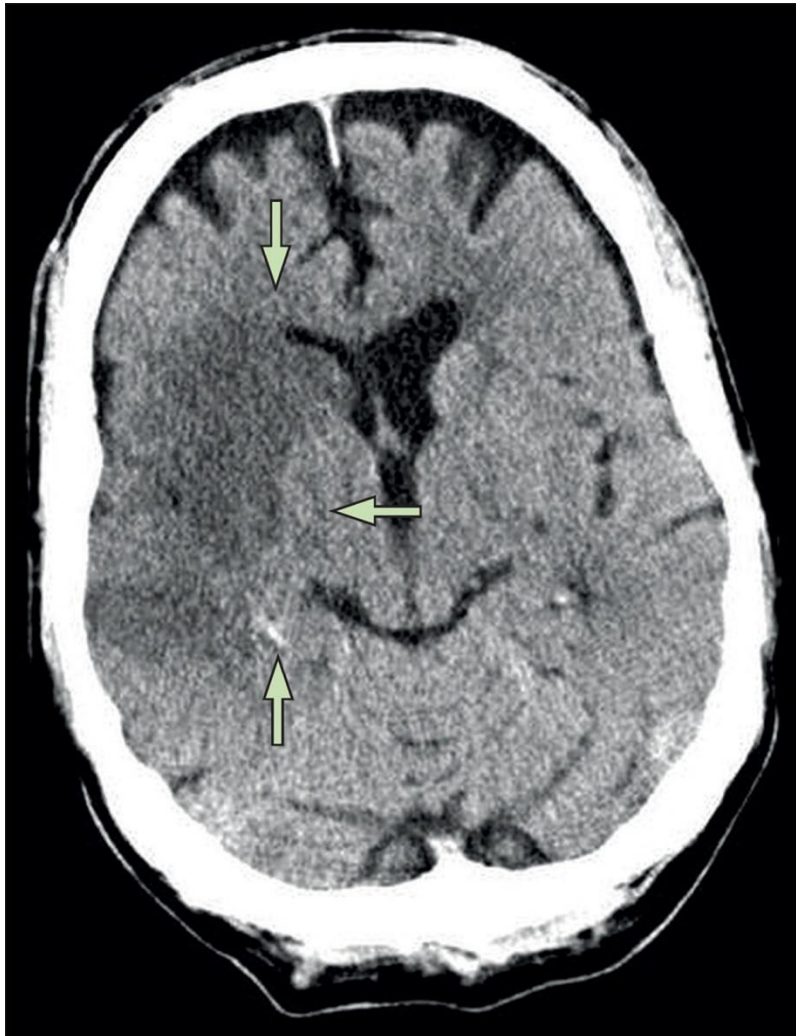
Non-Contrast CT of a Patient Presenting with a Right-Hemispheric Stroke Syndrome
